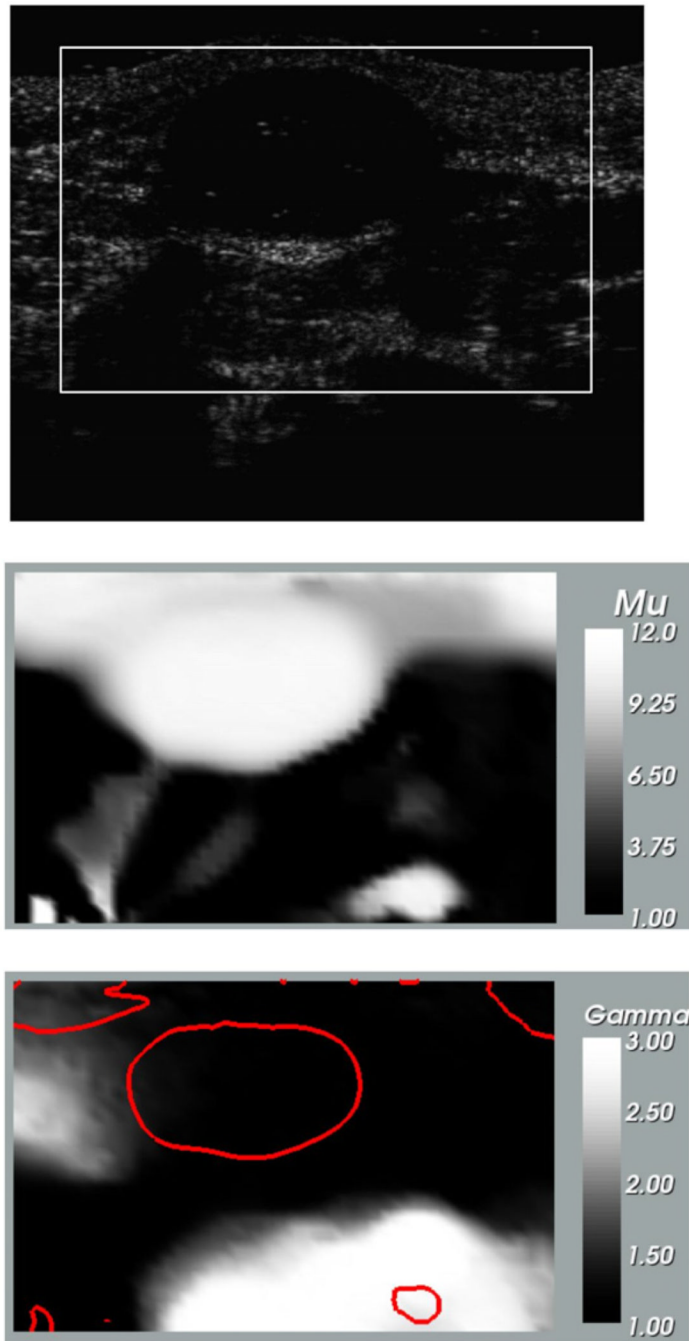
Images for fibroadenoma. Top: B-mode ultrasound image at small strain; middle: relative shear modulus at zero strain (μ_0); bottom: nonlinear parameter (γ). The dark curve represents the iso-contour of $\mu = 10$ and is plotted to locate the tumor in the nonlinear parameter image.
